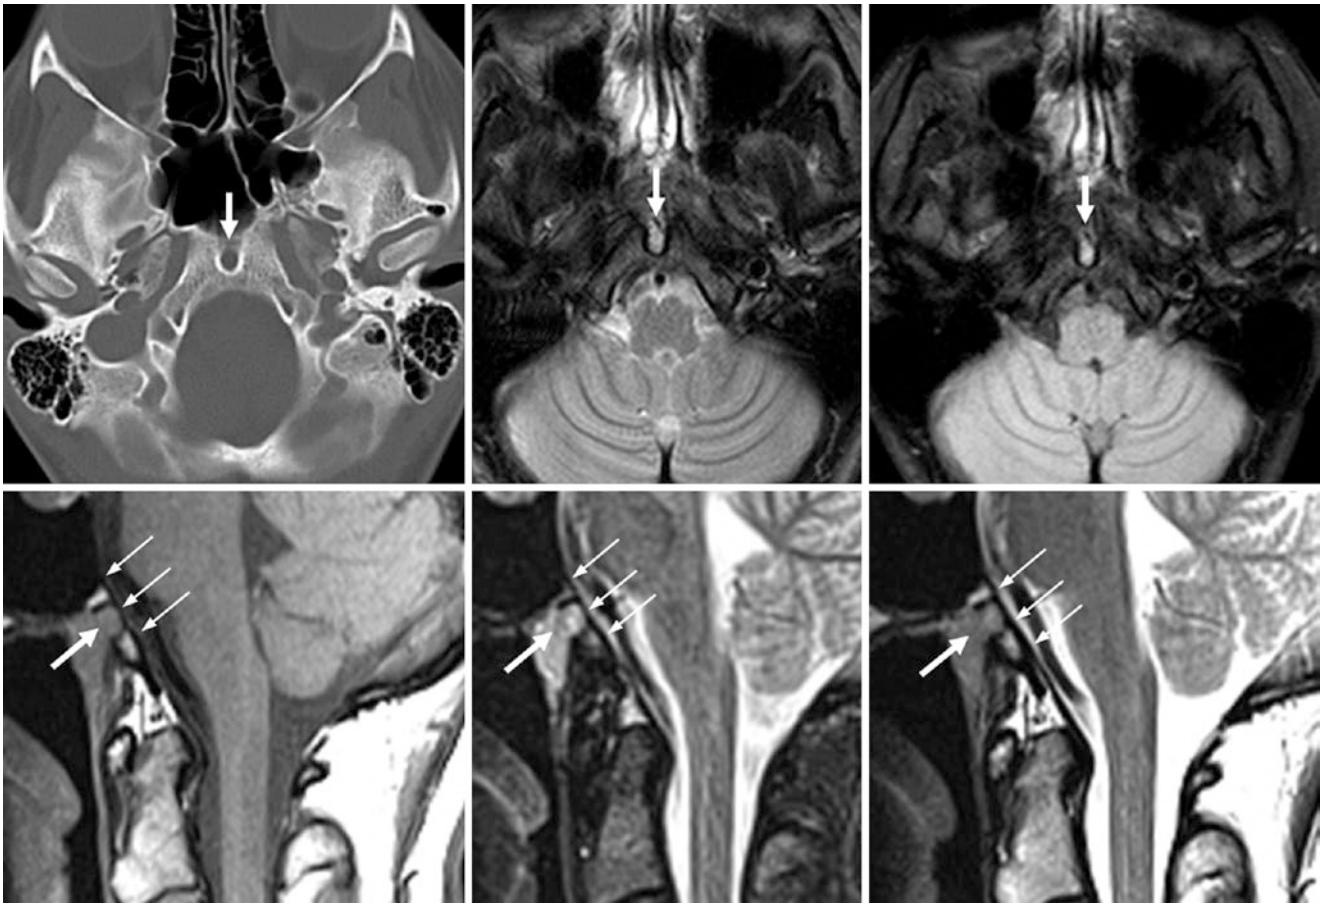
Top row:* A 23 year old with axial NECT (*left*) and T2WI (*middle*) and FLAIR MRI (*right*), which show bright signal within a FP from a CBM. *Bottom row:* on sagittal T1WI (*left*), STIR (*middle*), and T2WI (*right*), the FP/CBM extends through to the dura (*thin arrows*)
